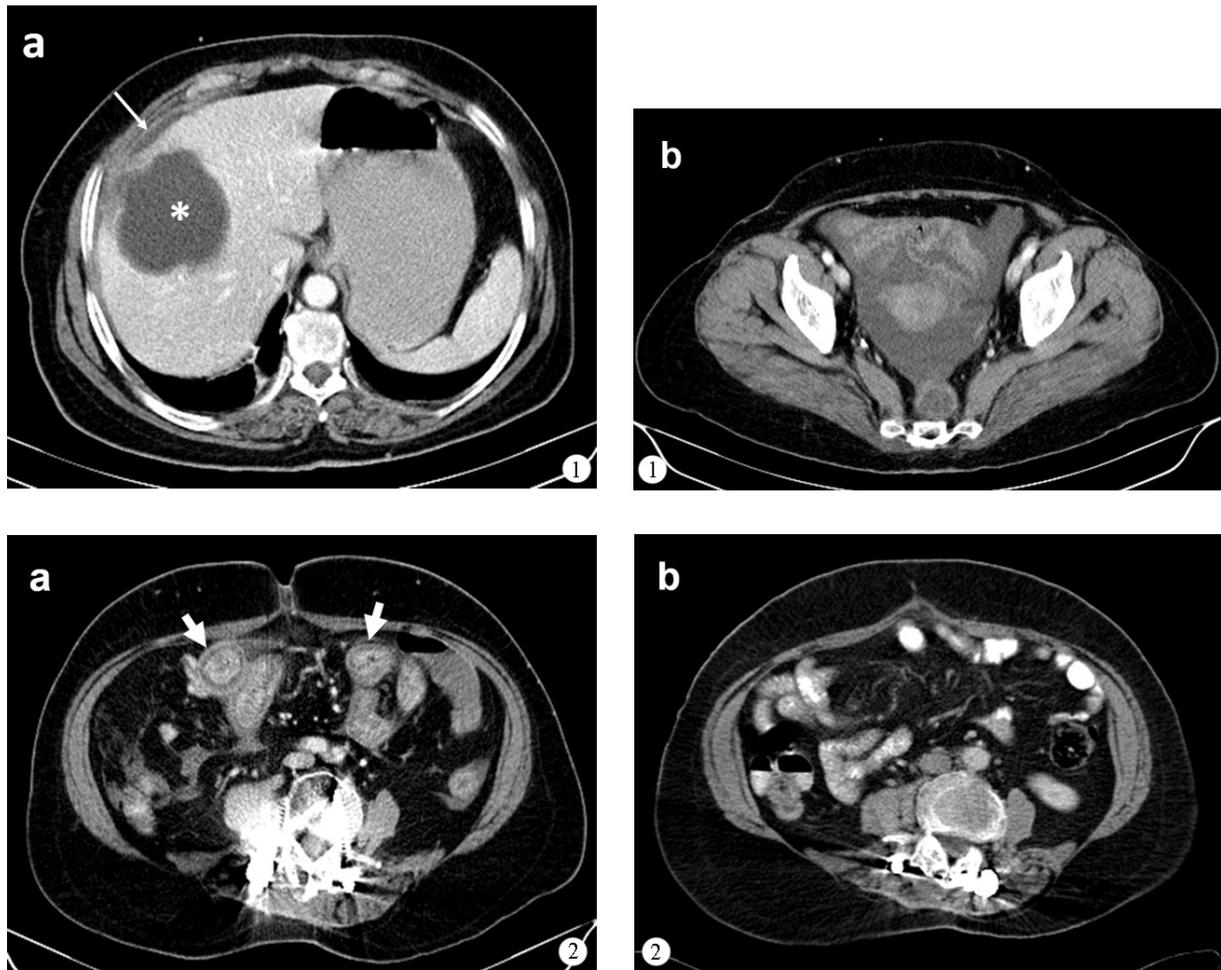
Axial contrast enhanced computed tomography images demonstrate ruptured hydatid lesion within right liver lobe (asterisk), perihepatic free fluid (thin arrow) (a) and free serous pelvic fluid (b). 2. Axial contrast enhanced computed tomography image shows diffusely thickened jejunal segments (short arrows) (a); one year follow up computed tomography image demonstrates normal jejunal segments some dilated with oral contrast material (b).
